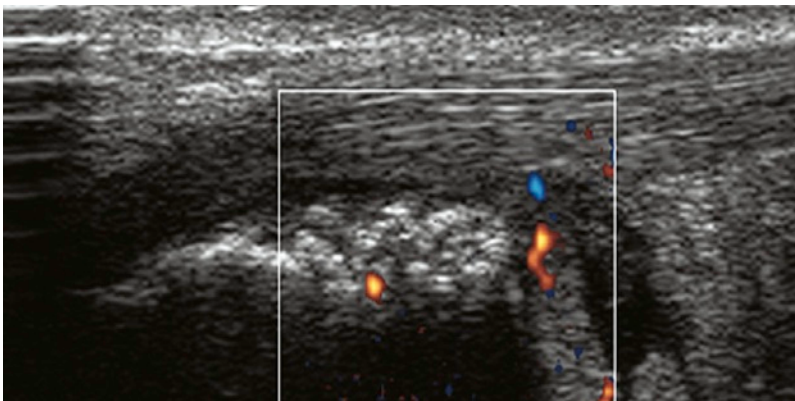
7 Ultrasound shows an inflammatory enthesis in a 13-year-old girl. The inflammation is detected by power Doppler in the calcaneus and in the bursa.
